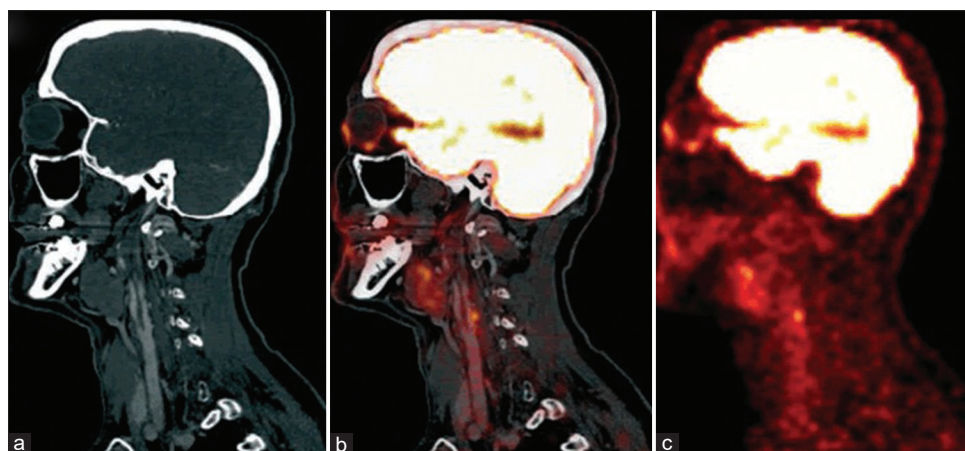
Computed tomography angiography (a), fused positron emission tomography/computed tomography (b) and positron emission tomography alone (c) demonstrating a left carotid plaque in a symptomatic patient showing high ^{18}F -FDG uptake
